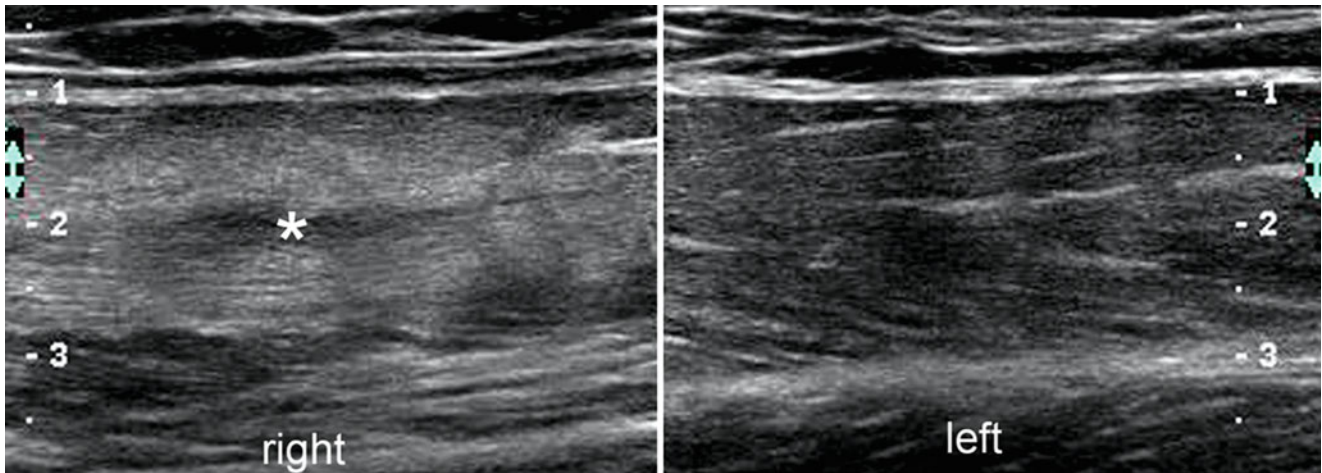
Partial-thickness tear. Grey scale ultrasound image (longitudinal view, side by side view, anterior thigh) shows a hypoechoic band (*) that corresponds to a partial tear in the right rectus femoris
